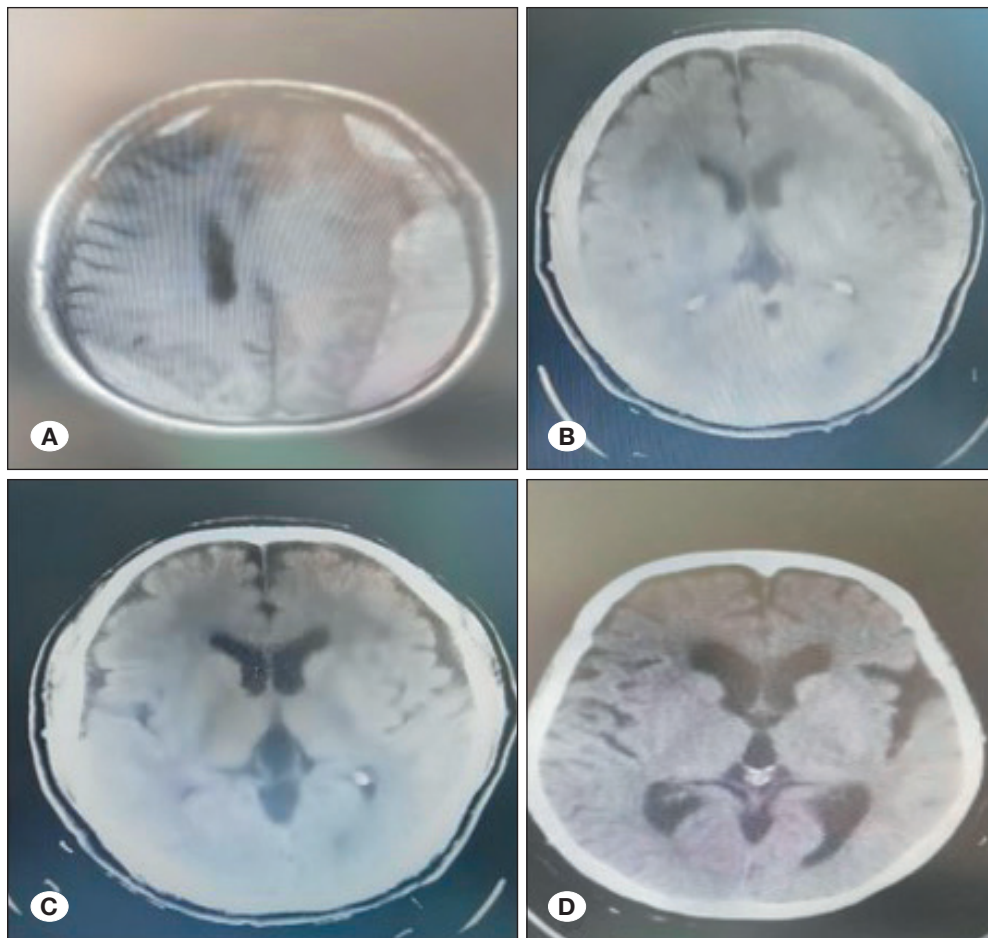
Follow-up CT scan image of patients. A) This preoperative CT scan image demonstrates chronic subdural hematoma (CSDH) with significant midline shift and mass effect. The hematoma appears hyperdense, indicating the presence of fresh blood within the subdural space. B) This image shows the subdural hematoma prior to the administration of atorvastatin and surgical drainage. The hematoma is still present with evident separation and layering within the subdural space. C) The postoperative CT scan indicates successful drainage of the subdural hematoma. The brain re-expansion is evident, though there may still be some residual pneumocephalus present. D) The follow-up CT scan demonstrates a significant reduction in the size of the hematoma and improved midline shift. The brain re-expansion appears satisfactory with minimal residual subdural fluid.
